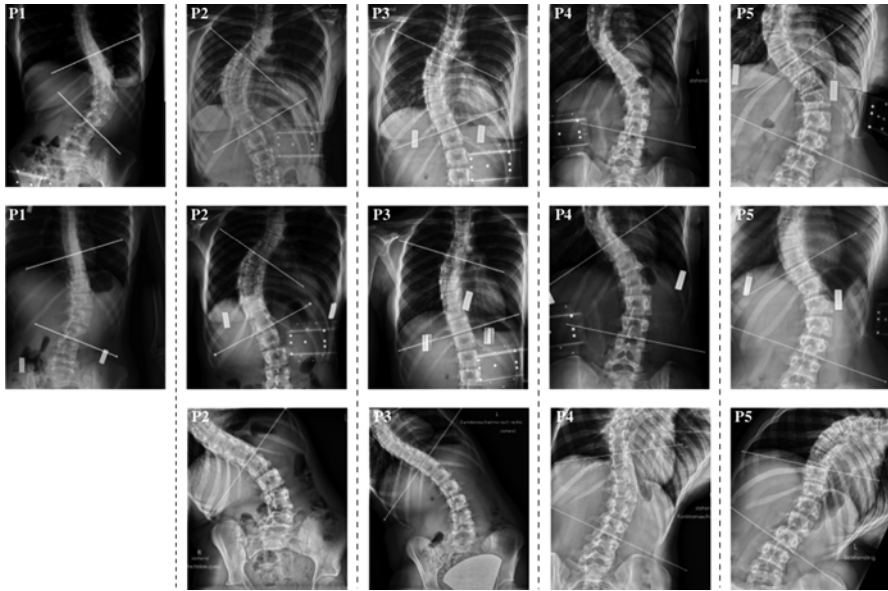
Cobb angle measurements. *First row:* anteroposterior radiographs in normal upright position. *Second row:* Pure axial quasi-static tractive load corresponding to 30 % of the patient's body weight generated by the proposed SLS. *Third row:* Lateral bending posteroanterior radiographs. It is important to note that the patient P1 did not perform the lateral bending test and, therefore, could not be included in this study (Reproduced from Elias de Oliveira [15] with permission)
